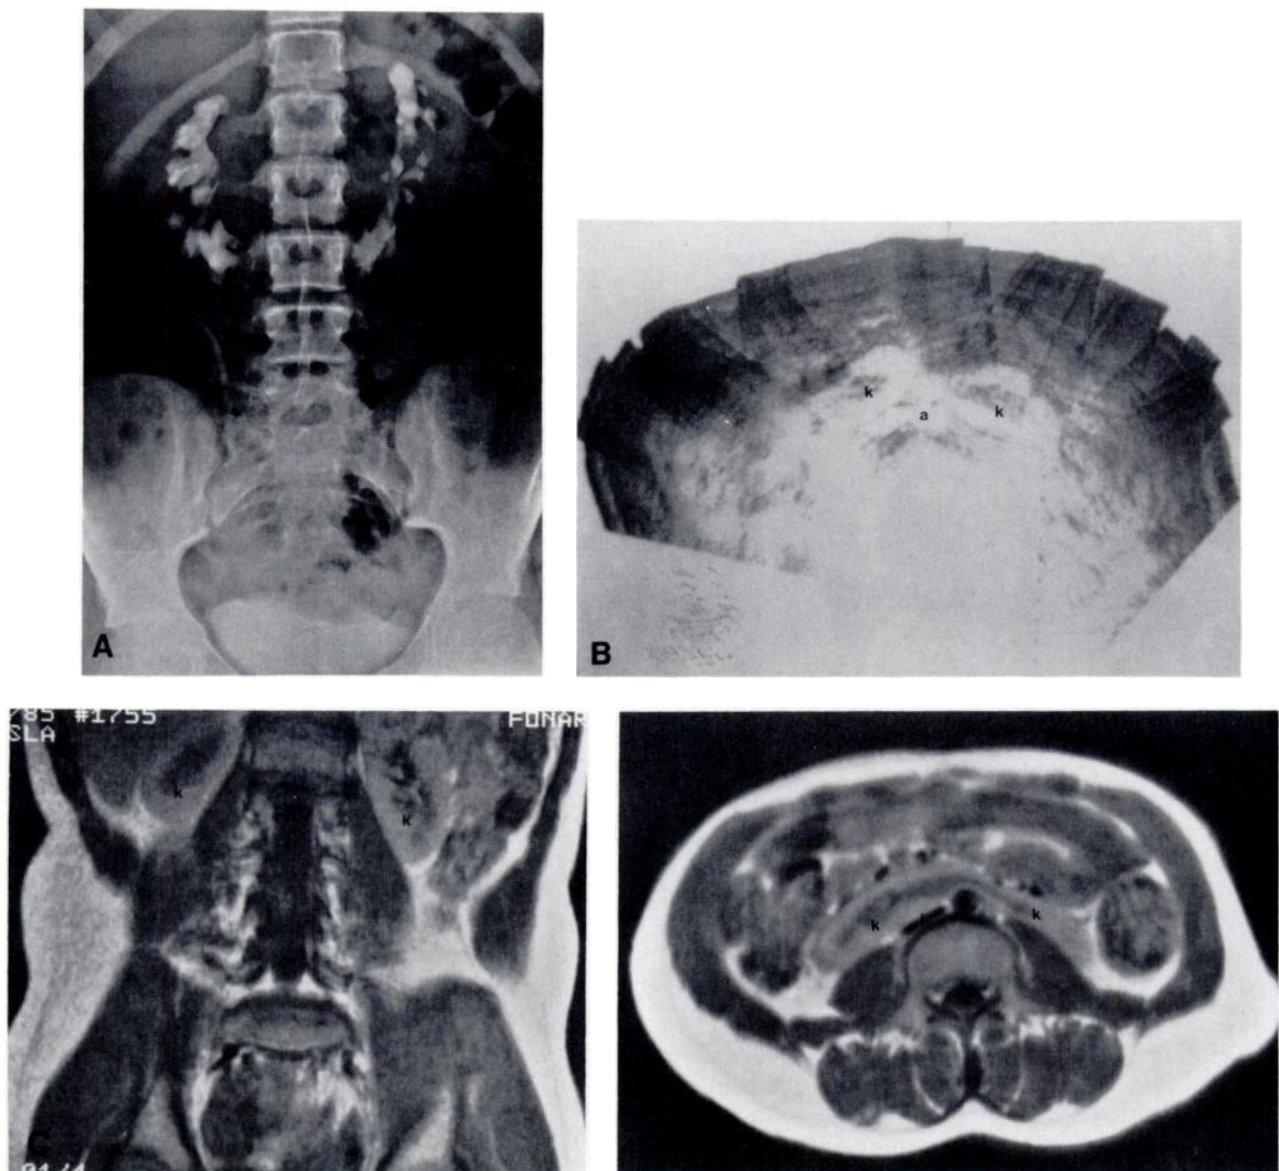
Horseshoe kidney. A, IVP shows reversal of normal axes of kidneys, with closer proximity of lower poles than upper poles. B, Ultrasonography, axial plane, shows proximity of lower poles of kidneys (k) anterior to aorta (a). C, Magnetic resonance image, coronal plane (SE 300/
